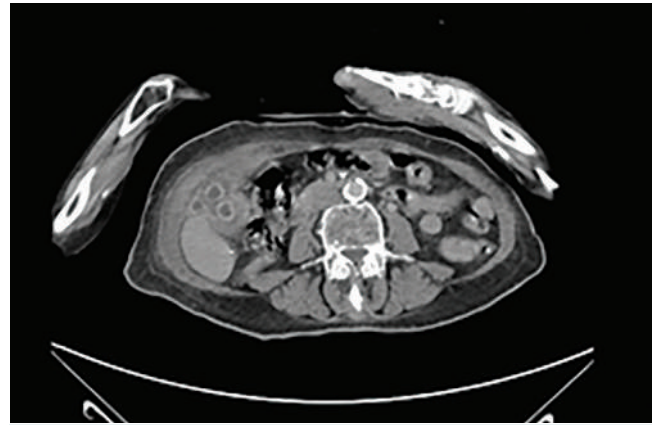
Preoperative CT image. Preoperative CT scan shows a cholecystocutaneous fistula.
